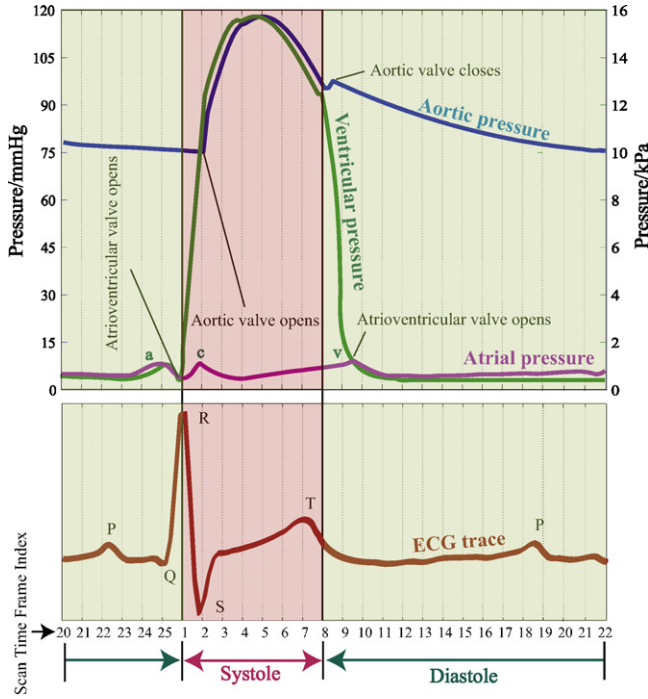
Cardiac events with relation to scan time frames. The pressure waveforms of the left ventricle, aorta and right atrium is correlated to the scan time frames of gated-MRI. The triggering of image acquisition starts at the occurrence of the R-wave. For a temporal resolution of 25 time frames, the cardiac systole starts from 1 to 8, and the diastole is from 9 to 25. The pressure changes in the atria can be denoted by the minor elevations labelled as *a*, *c*, and *v* waves that are caused by the dynamics of blood during atrial and ventricular contractions.
